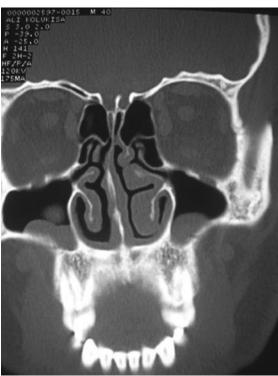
Serial sections of coronal computed tomography scan, showing bilateral bifid inferior turbinate and the absence of bilateral uncinate process.
